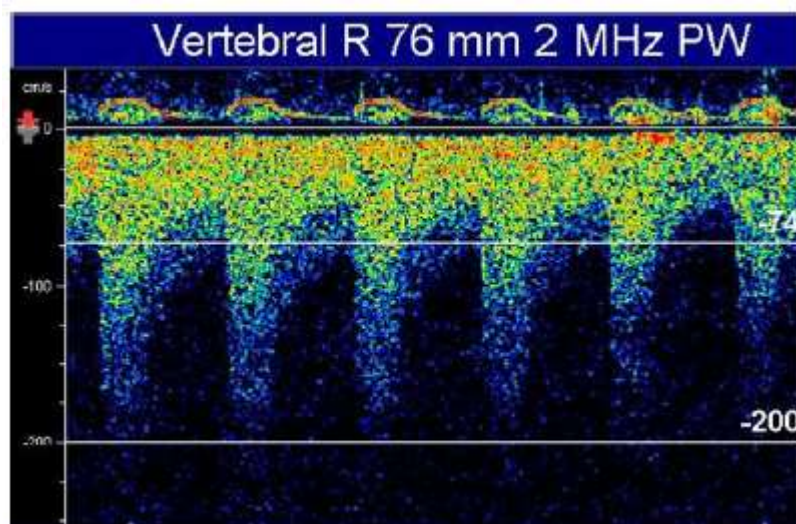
Right vertebral artery, foraminal window, transcranial Doppler, with high velocity showing stenosis.
